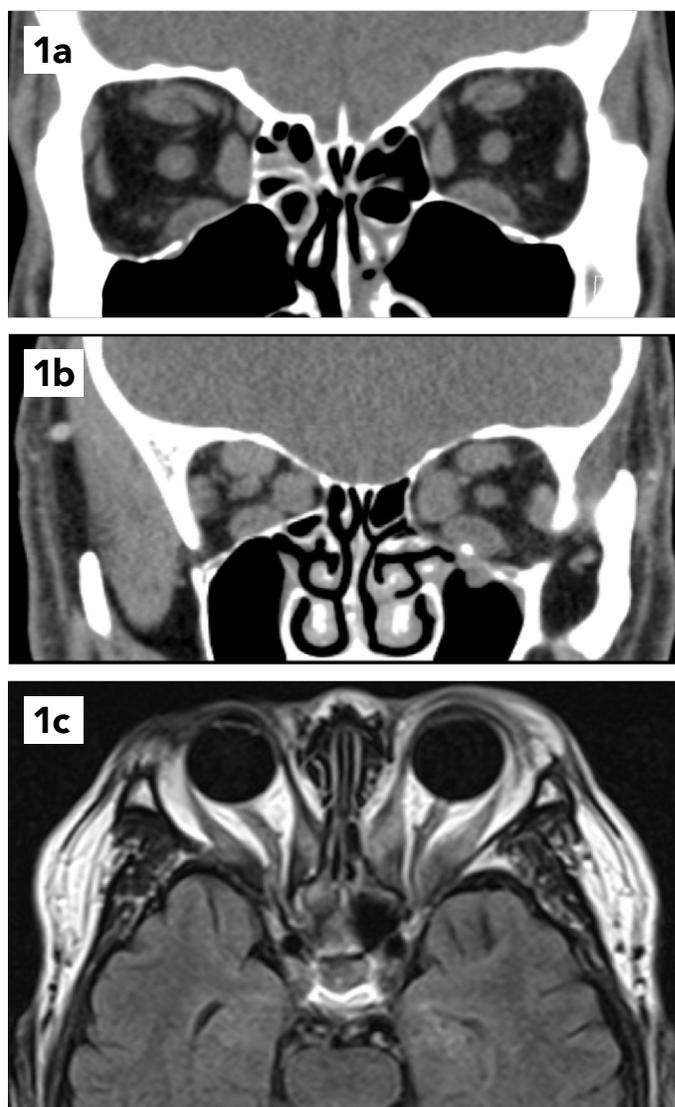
A. Coronal CT without contrast showing bilateral enlargement of the inferior rectus, medial rectus and superior rectus-levator complex with sparing of lateral rectus. No apical crowding. B. Coronal CT without contrast showing apical crowding. C. Axial MRI T2 flair showing enlargement of bilateral medial and lateral rectus with tendon sparing and enhancement indicating inflammation with the muscles. Neuroimaging used for diagnosis; courtesy of Sabrina Yu, MD & Vivian T. Yin, MD.
